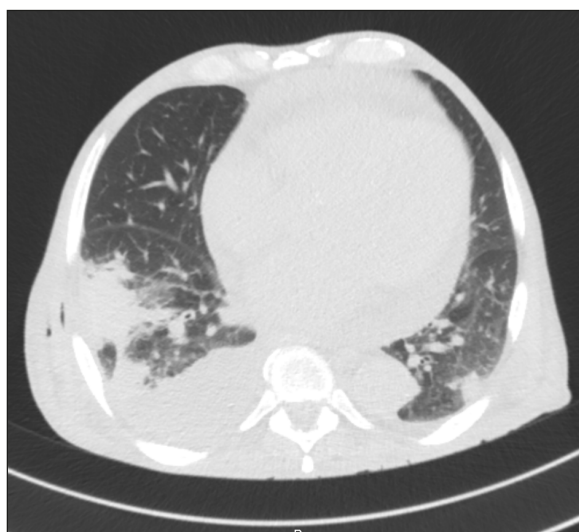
Chest computed tomography revealing pulmonary involvement during the second episode of febrile neutropenia.
